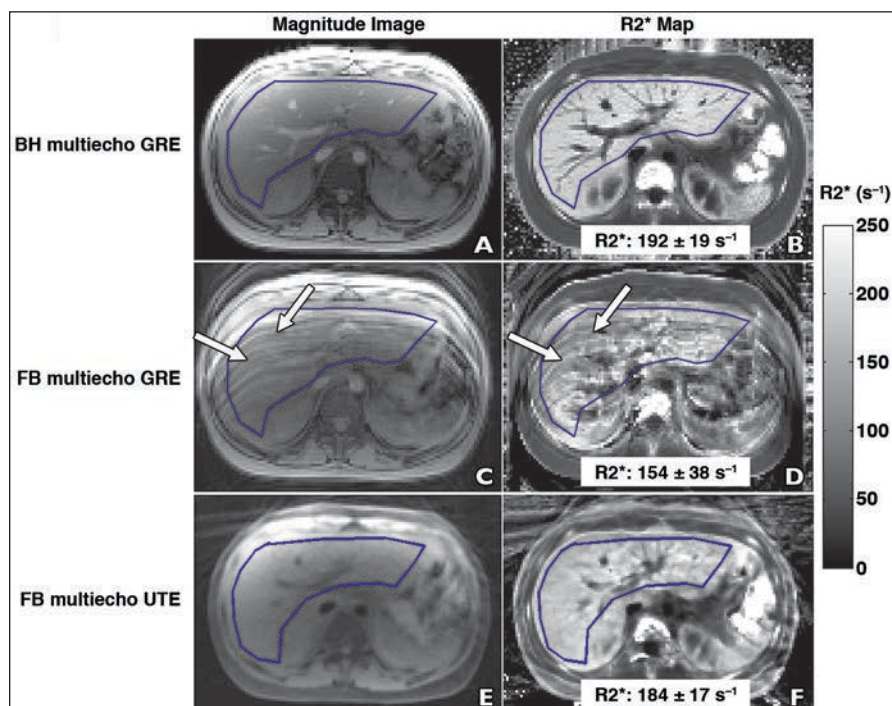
13-year-old girl with sickle cell disease and mild iron overload who, as control patient, had breath-hold (BH) and free-breathing (FB) MRI sequences compared. A–F, First-echo magnitude MR images of liver (A, C, and E) and respective $R2^*$ maps (B, D, and F) acquired by BH multiecho gradient-recalled echo (GRE) (A and B), FB multiecho GRE (C and D), and FB multiecho ultrashort TE (UTE) (E and F) imaging. For each acquisition, mean $R2^*$ (\pm SD) was calculated for whole-liver ROI (blue outline, A–F) after exclusion of blood vessels by histogram analysis. BH multiecho GRE $R2^*$ MRI–based hepatic iron content (HIC) of 5.4 mg Fe/g of dry liver weight (calculated using calibration equation in [36]) served as reference standard because existing calibration curves were derived from such examinations. Typical FB multiecho GRE motion artifacts (arrows, C and D) are seen. For FB multiecho GRE acquisition, $R2^*$ values are lower and SD is higher than values for BH multiecho GRE and FB multiecho UTE acquisitions. Note that $R2^*$ value obtained using FB multiecho UTE imaging is in close agreement with that obtained using BH multiecho GRE imaging, which suggests that FB multiecho UTE acquisition provides accurate results under FB conditions. Applying BH multiecho GRE $R2^*$ HIC calibration equation [36] to respective $R2^*$ values results in apparent HIC of 4.2 mg Fe/g of dry liver weight for FB multiecho GRE imaging and 5.1 mg Fe/g of dry liver weight for FB multiecho UTE imaging.
